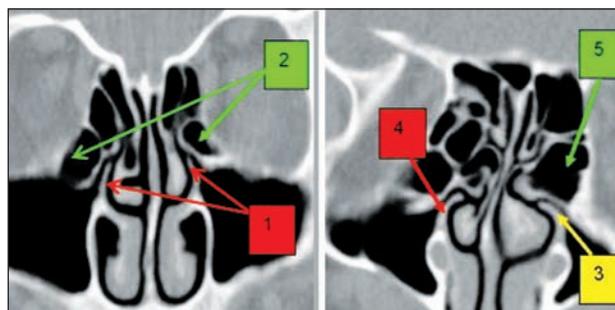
Paranasal sinuses CT scan, bone window, coronal slice. 1. normal angulation of the left uncinete process, right verticalization (lateralization); 2. bilateral Haller cell; 3. medialized left uncinete process (horizontalized); 4. normal angulation of the right uncinete process; 5. giant left ethmoid bulla
